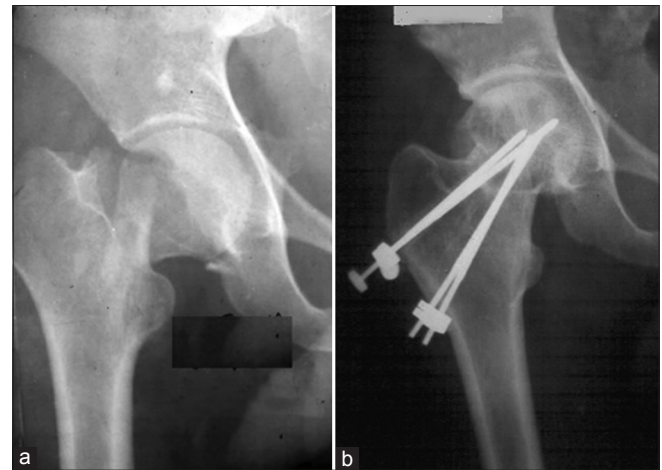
Radiograph of right hip joint of a 22 year old male showing (a) nonunion since one year; neck shaft angle 95°, (b) the status at five years followup showing; neck shaft angle 130° and union has been achieved
